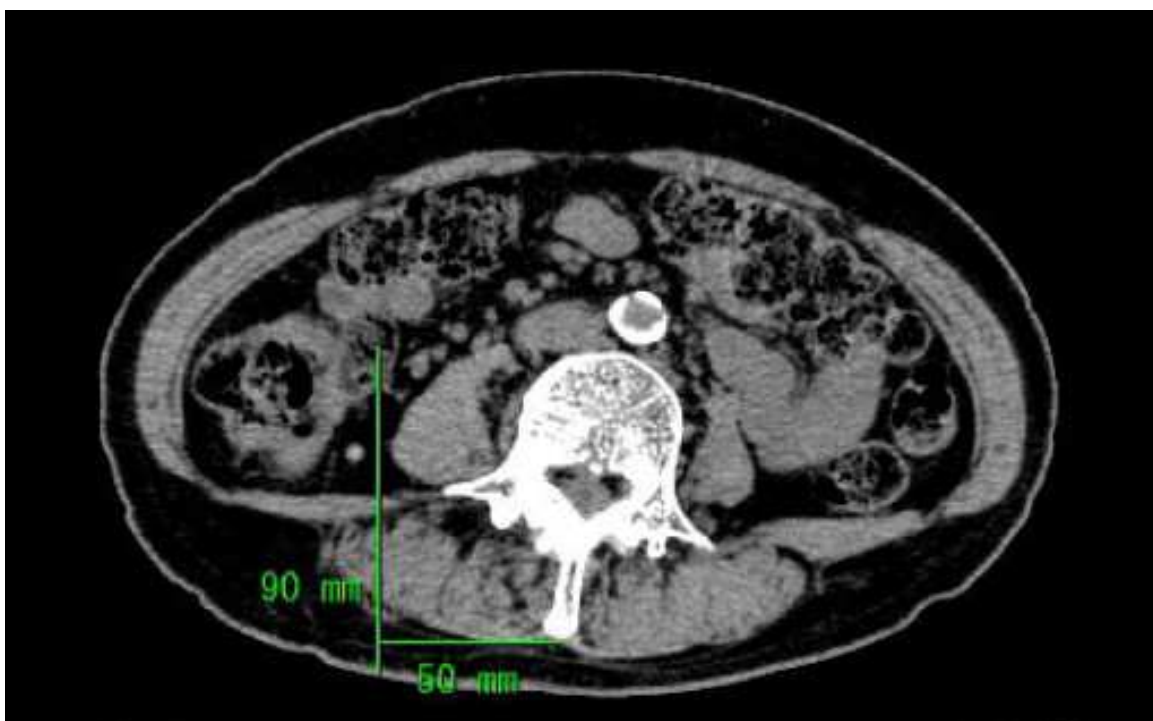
Computed tomography of the 4th lumbar spine level from a 70-year-old female. Similarly, the needle would have penetrated the peritoneal cavity if the needle had been advanced as suggested by the textbook.
